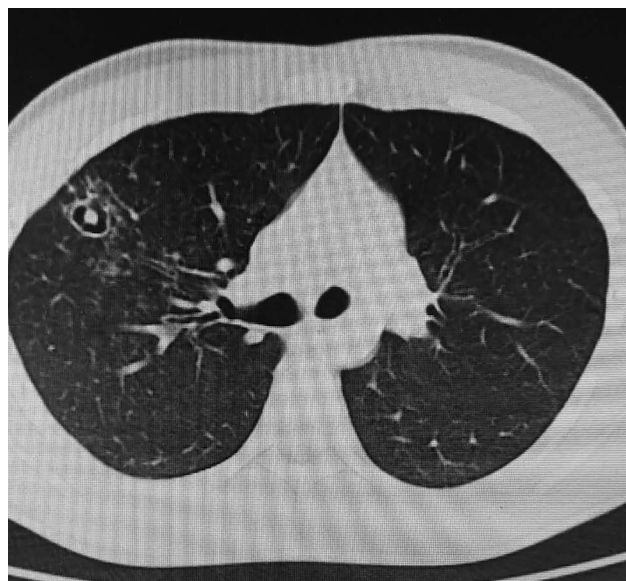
Initial CT findings.
